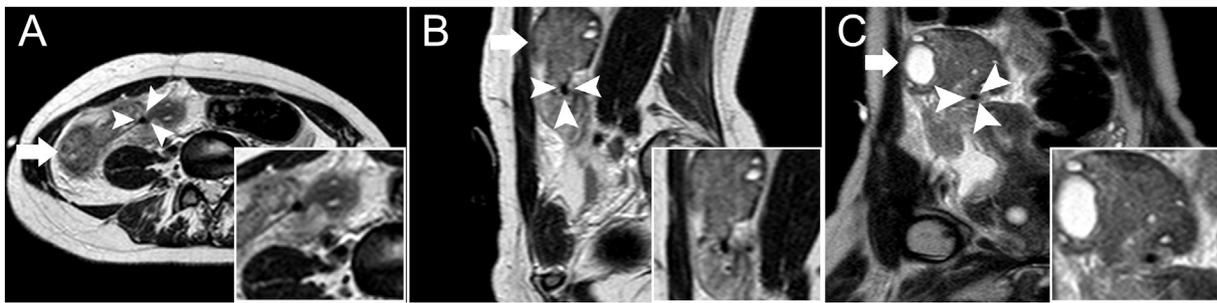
A 15-year-old girl with right ovarian torsion. Axial (A), sagittal (B), and coronal (C) T2-weighted MR images demonstrate enlarged right ovary (arrows) and presence of “whirlpool sign”. The “T2-hypointense dot sign” (arrowheads) is also noted (arrowheads).
